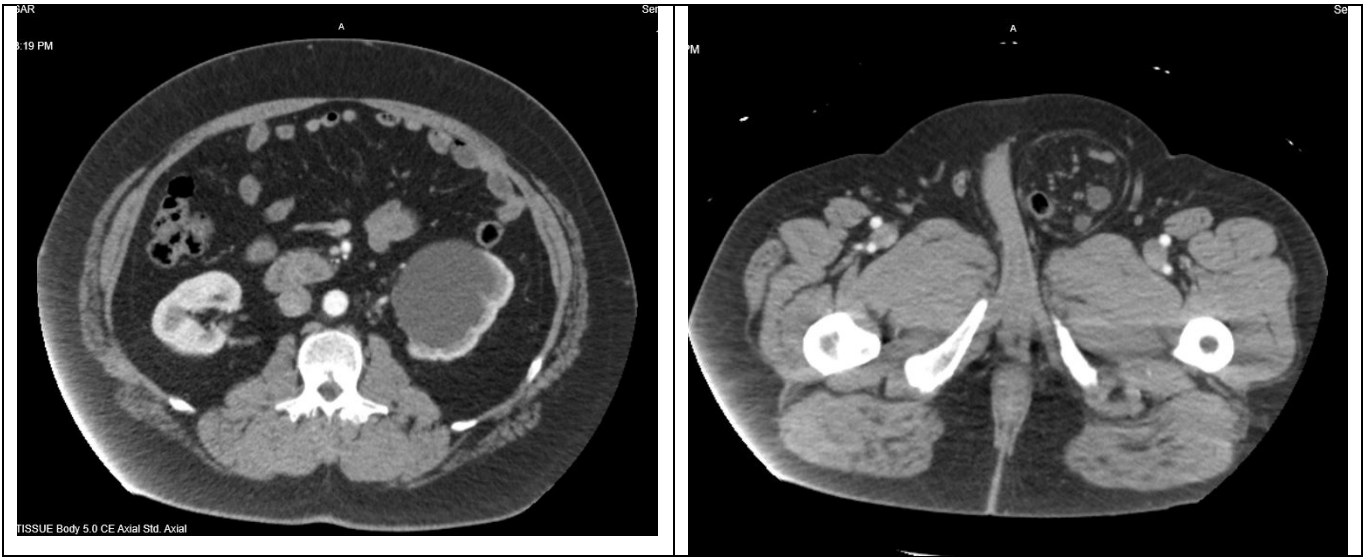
Cross sectional images of patient's CT scan on presentation. Left sided hydronephrosis was identified to be caused by ureteral herniation.
